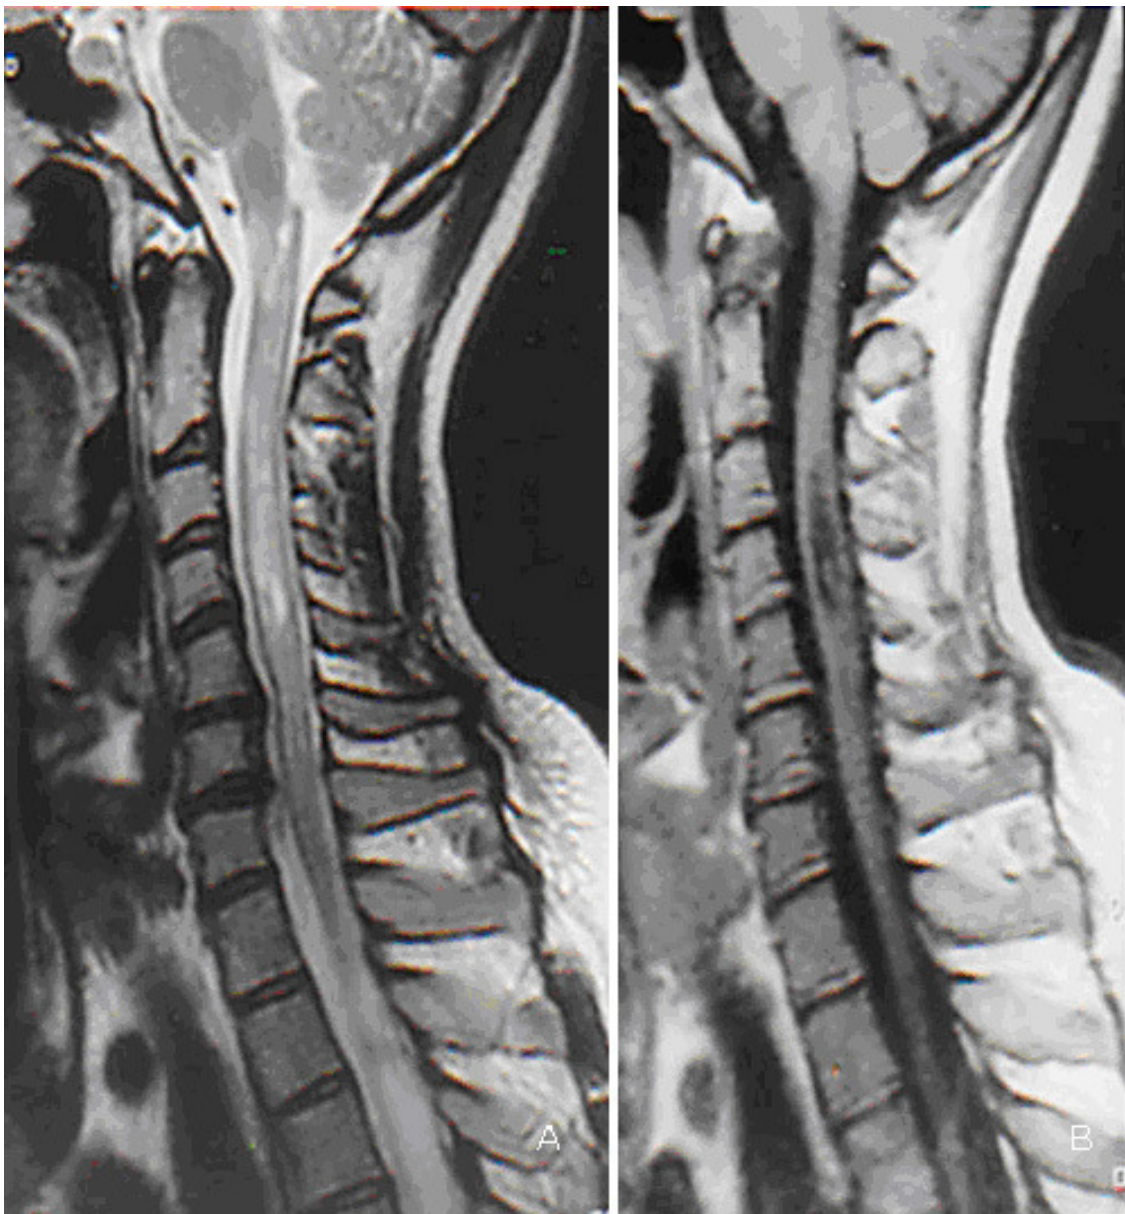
A 9-year-old boy suddenly developed flaccid tetraparesis with respiratory insufficiency and refractory hiccups. MRI showed LETM in the anterior part of the cord. CSF was normal, OCB were negative, biochemical parameters and immunological work up were unremarkable. After corticosteroid treatment and plasmapheresis he was better, there was no more need for ventilation, and he was partially able to move his extremities. LEMT with respiratory insufficiency, as well as brain MRI findings pointed to the diagnosis of NMO.
